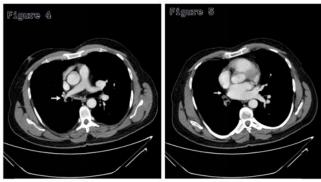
CT section of the mediastinal window showing complete attenuation of branches of right pulmonary artery.
